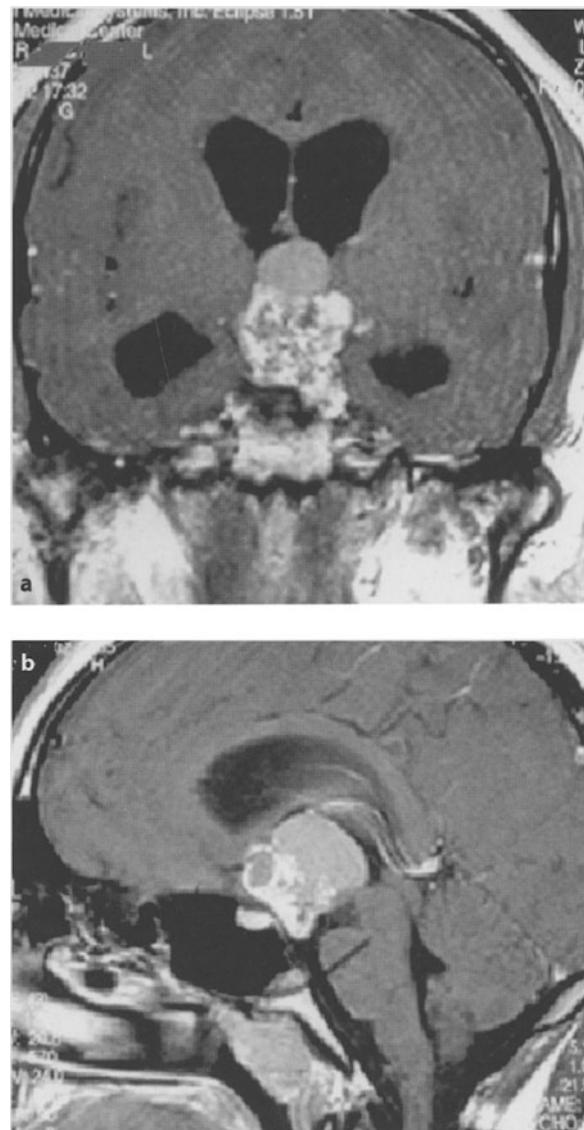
Craniopharyngioma. a Sagittal and b coronal T1-weighted images after administration of gadolinium. The tumor extends into the third ventricle causing obstruction of the CSF flow
